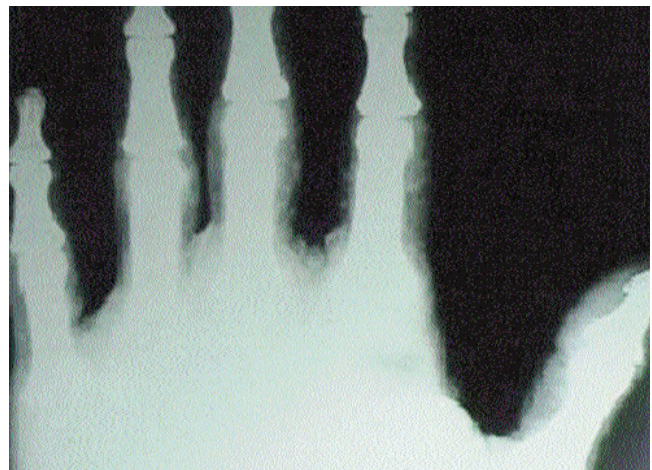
The digits soft tissue Xeroradiography that demonstrates soft tissue with appropriate clarity to compare with current radiography.
